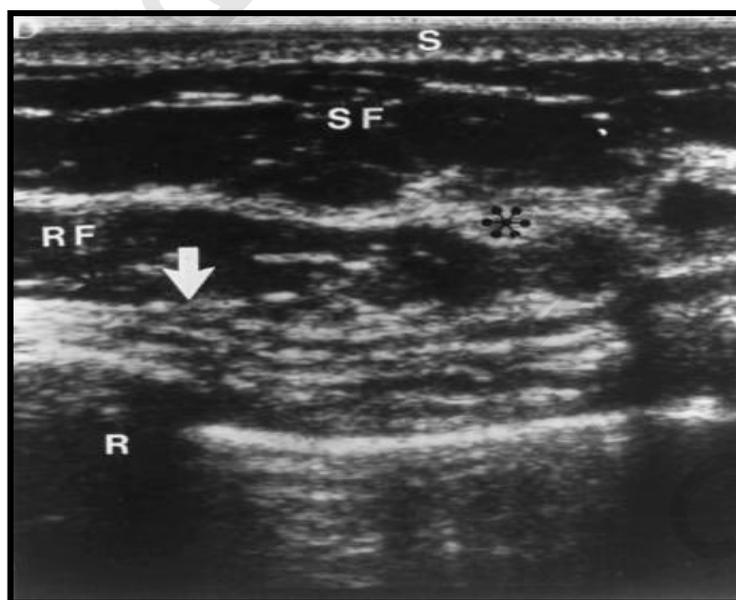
Normal sonographic anatomy of the breast.⁽¹¹⁾
